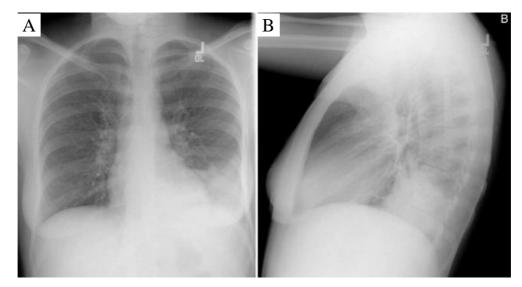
Anteroposterior (A) and lateral (B) radiographs from a child with a left lower lobe infiltrate
